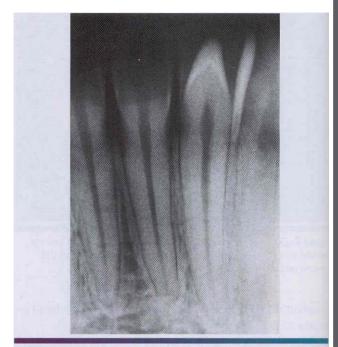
• Talon cusp. Radiograph of a talon cusp on a mandibular lateral incisor. Note the enamel and dentin layers within the accessory cusp.
